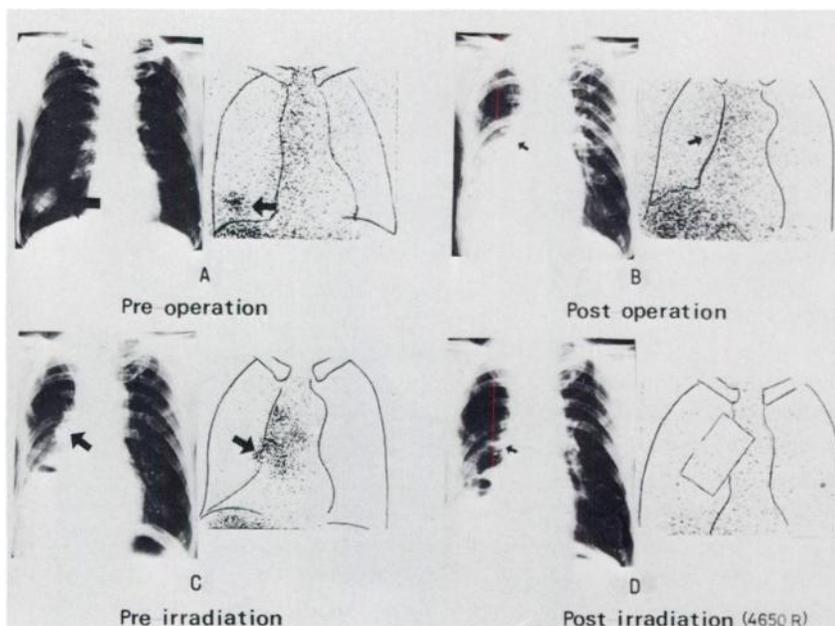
Case 2. Pulmonary carcinoma. Chest x-ray (A) shows nodular shadow in right lower lobe (indicated by arrow). Scintigram taken 48 hr after administration of 2.0 mCi of ^{67}Ga -citrate reveals positive scan corresponding to shadow on chest x-ray. Postoperative chest x-ray (B) and ^{67}Ga scintigram (B) were obtained 6 months after operation. Scintigram reveals questionable lesion in right hilar region (indicated by arrow). Chest x-ray (C) and ^{67}Ga scintigram (C) were taken 1 month later. Scintigram revealed definite lesion in right hilar region. Chest x-ray (D) and ^{67}Ga scintigram (D) obtained after ^{60}Co irradiation. Uptake of ^{67}Ga in tumor of right hilar region is diminished after radiotherapy.
